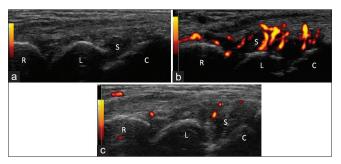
Serial ultrasound assessments of right wrist in a 37-year-old female patient with RA (long-axis dorsal view). (a) At month 12 of full-dose biologics treatment: No PD flow. (b) At week 24 after biologics dose reduction: Synovial PD flows significantly increased. (c) 20 weeks later after titrating back to full dose of biologics: Synovial PD flows decreased. S: Hypertrophied synovium, R: Radius, L: Lunate bone, C: Capitate bone, PD: Power Doppler. RA: Rheumatoid arthritis
